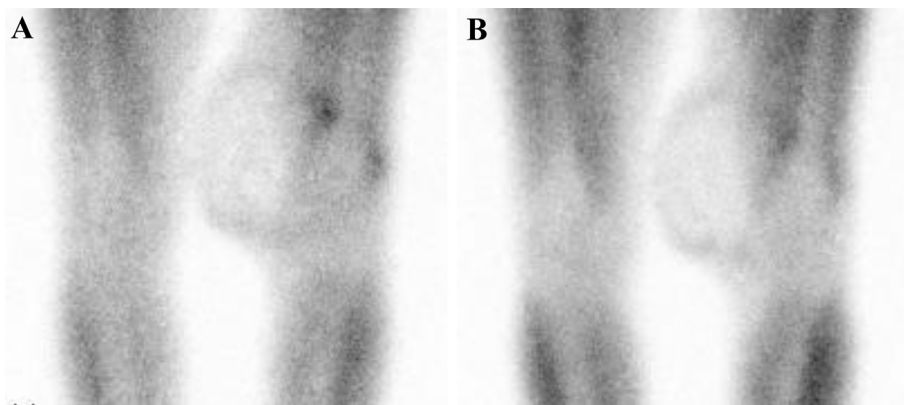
Thallium scintigraphy. (A and B) Early phase (A) and delayed phase (B) are shown. Thallium scintigraphy showed mild uptake on the tumor margins in both the early and delayed phase.
